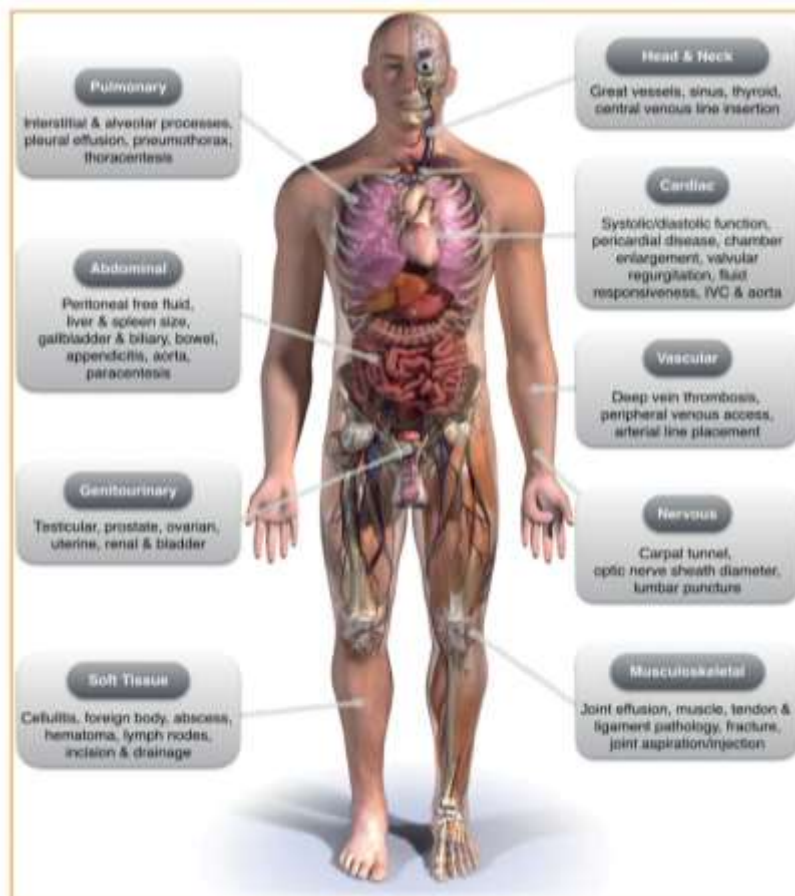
Point of care Ultrasound applications. ⁽⁵⁾
